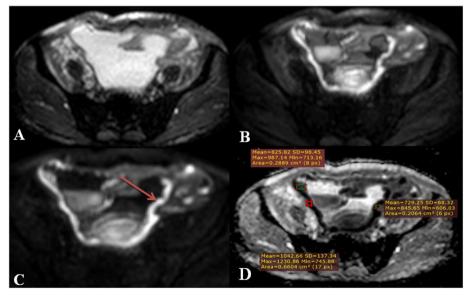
Fifty-four year old female patient with history of surgically excised ovarian cystadenocarcinoma presented by abdominal pain and distention. a DWI at b 0. b DWI at b 500. c DWI at b 1000. d ADC map. The images showed sheets of peritoneal thickening (arrow) with high signal in DWI and low in ADC map, impressive of restricted diffusion with average ADC value $0.83 \pm 0.08 \times 10^{-3}$ mm²/s. Final diagnosis after pathological examination was peritoneal metastatic deposits
